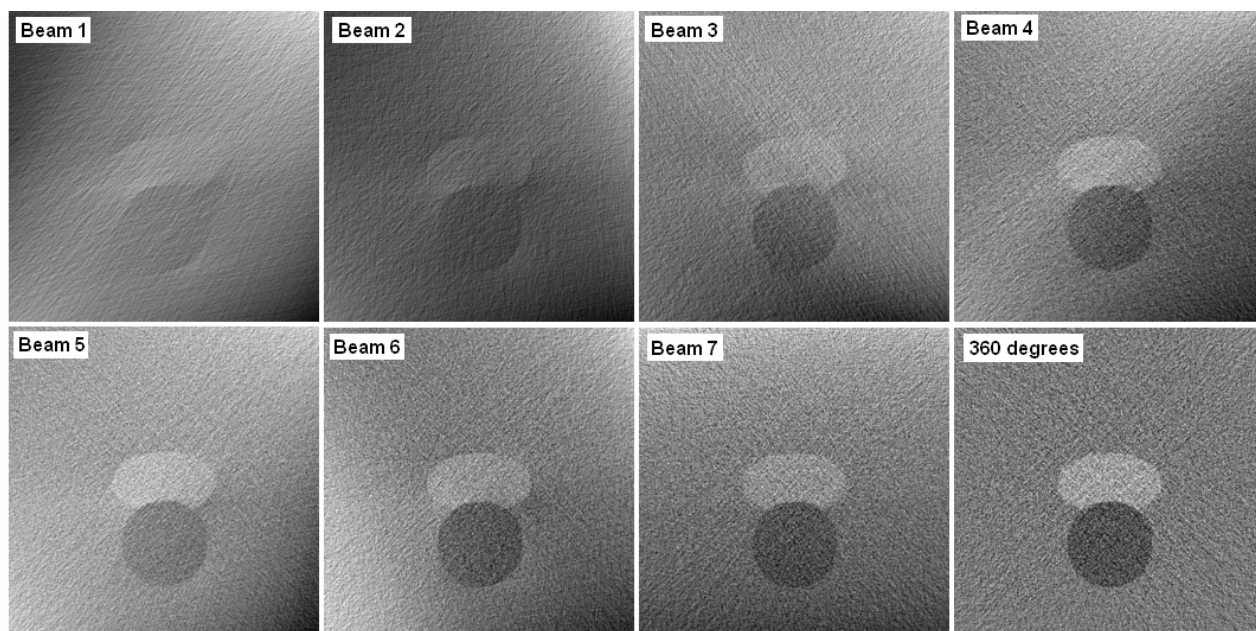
DTS images for the medium anatomical deformation obtained with the CBCT system mounted ORTHOGONALLY to the treatment beam. The axial slice going through the isocentre of the reconstructed DTS image at each treatment position (beam 1 to 7) is shown. For comparison purposes, the reconstructed image with the full imaging range of 360 degrees is also shown.
